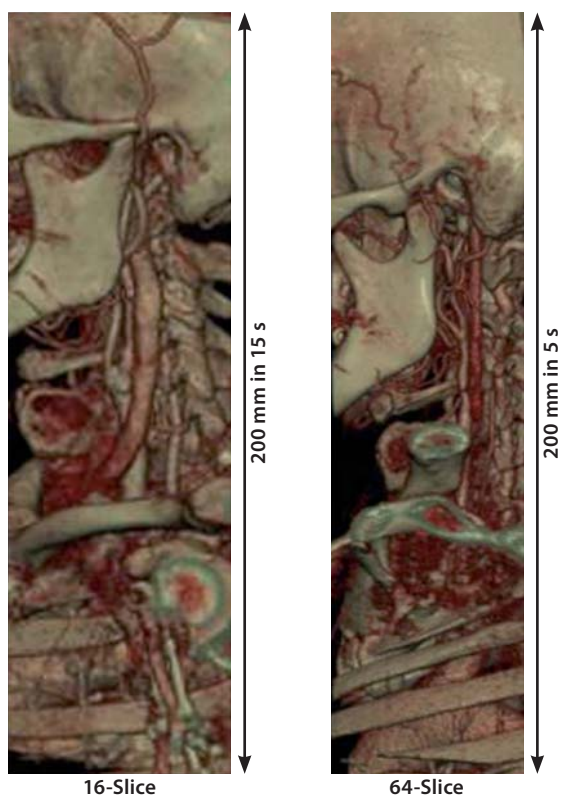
Direct comparison of a CT angiography of the carotid arteries in the same patient, performed with a 16-slice CT at 0.75-mm collimation and with a 64-slice CT using 0.6-mm collimation and double z-sampling technique. Image quality can be greatly improved using 64-slice CT and with significantly shorter scan times due to the absence of strong venous overlap. (Case courtesy of the University of Munich, Grosshadern Clinic, Germany)
